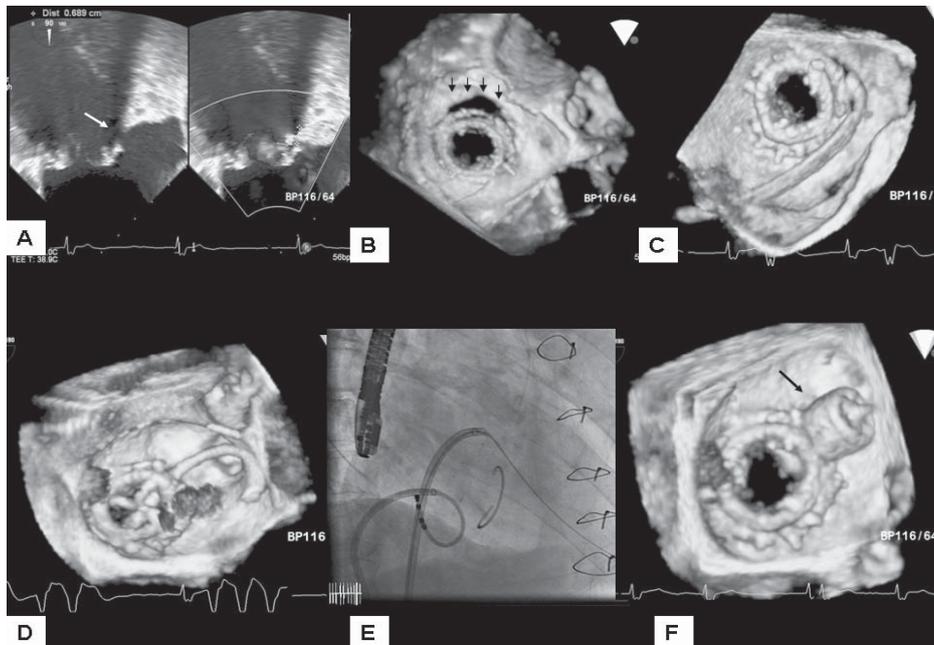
Sizing of the paravalvular defect (white arrow) by two-dimensional transesophageal echocardiography (TEE) which measured 4 mm. Fig. 1B. Three-dimensional transesophageal echocardiography (3DTEE) shows a much larger crescentic defect (black arrow heads). Figs. 1C and 1D are 3D TEE images showing devices crossing the defect compared to fluoroscopic imaging (Fig. 1E). Fig. 1F shows effective closure of the defect.
